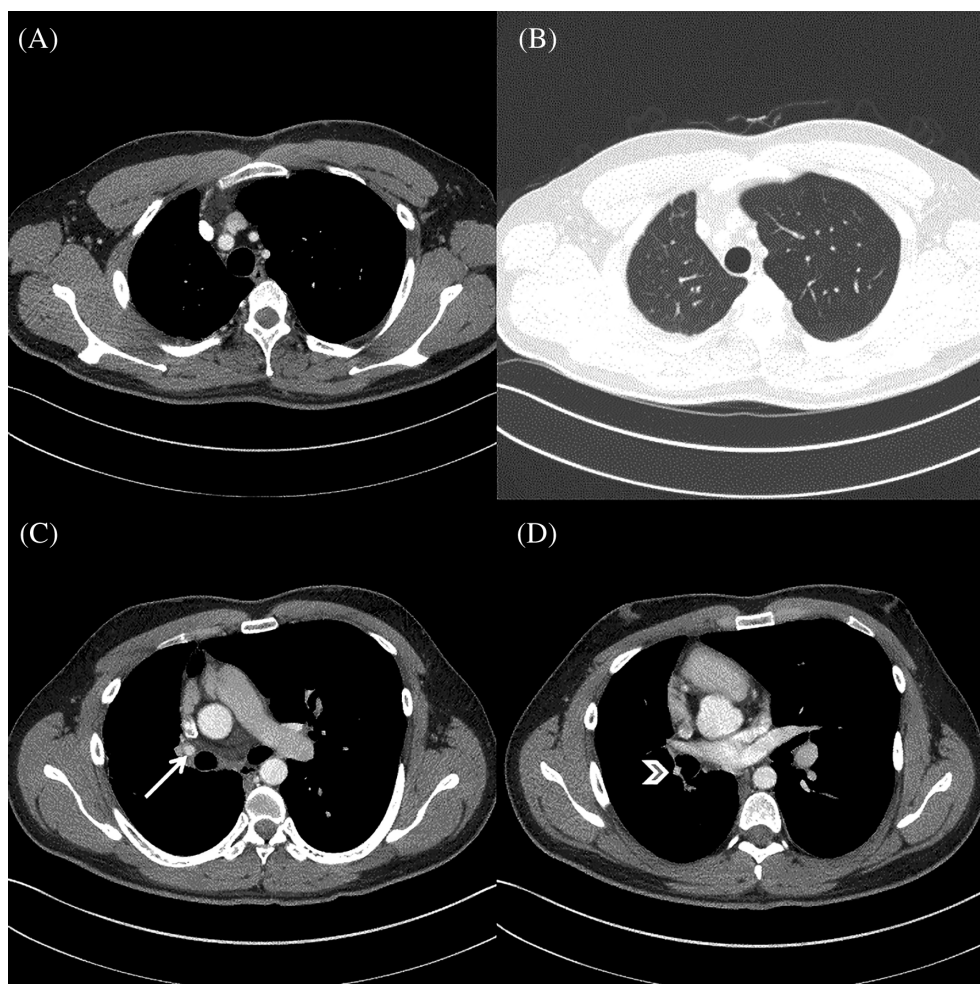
Computed tomography demonstrating small volume of right lung with mediastinal deviation to right side (A, B) and right pulmonary artery agenesis and bronchial artery aneurysm (arrow), hypertrophic change of bronchial artery (arrowhead) (C, D).
